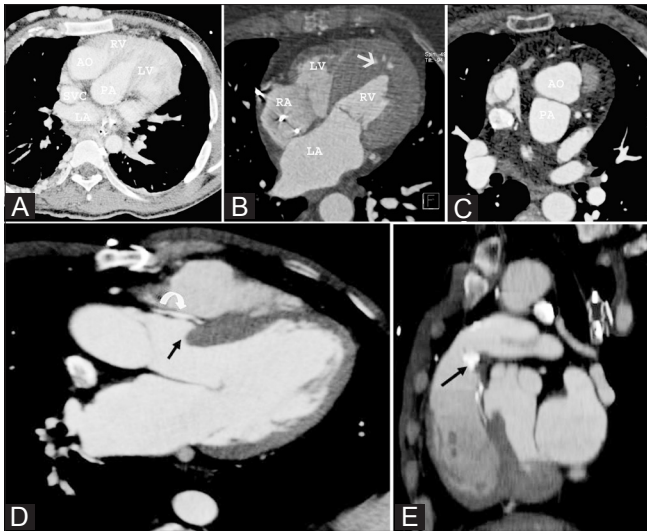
(A–E): Complex congenital anomalies. Four-chamber reconstructed CT image (A) shows the aorta (AO) located anterior and to the right of the pulmonary artery (PA). The aorta originates from the right ventricle (RV) and the pulmonary artery from the left ventricle (LV) in a patient with D-transposition of great arteries. Four-chamber reconstructed CT image (B) shows the left atrium (LA) draining into a hypertrophied morphological RV (systemic ventricle), which opens into the aorta. Moderator band is seen in the RV (arrow). The right atrium (RA) is draining into the morphological LV (pulmonic ventricle), which opens into the pulmonary artery. Axial CT image (C) in the same patient at a higher level shows the aorta located anterior and slightly to the left of pulmonary artery, which is consistent with levotransposition. Three-chamber reconstructed CT image (D) in a patient with repaired tetralogy of Fallot shows a patch repair of the VSD (curved arrow) and partial overriding of the aorta (straight arrow) over the inter-ventricular septum. Sagittal reconstructed CT image (E) in the same patient shows calcified pulmonary conduit (arrow)
